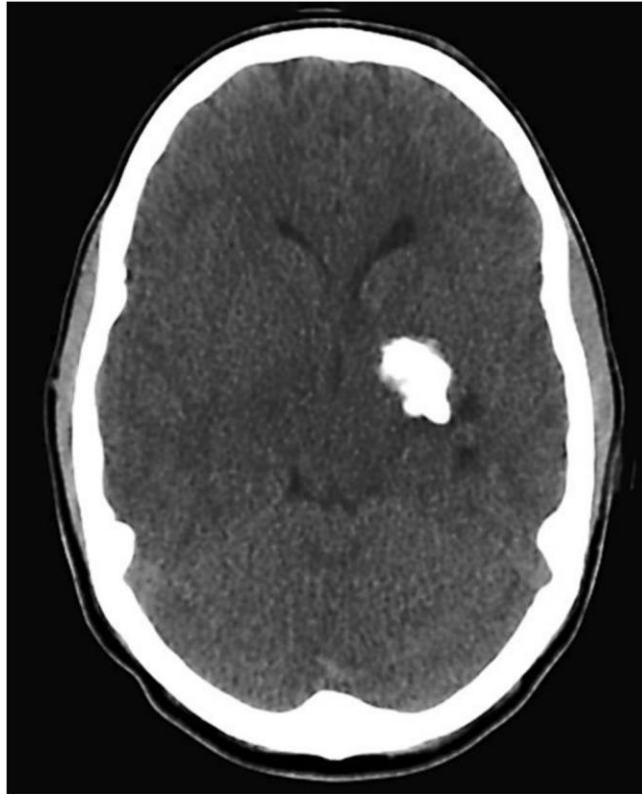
Preoperative transverse computed tomography image indicating a calcified lesion abutting the temporal horn
